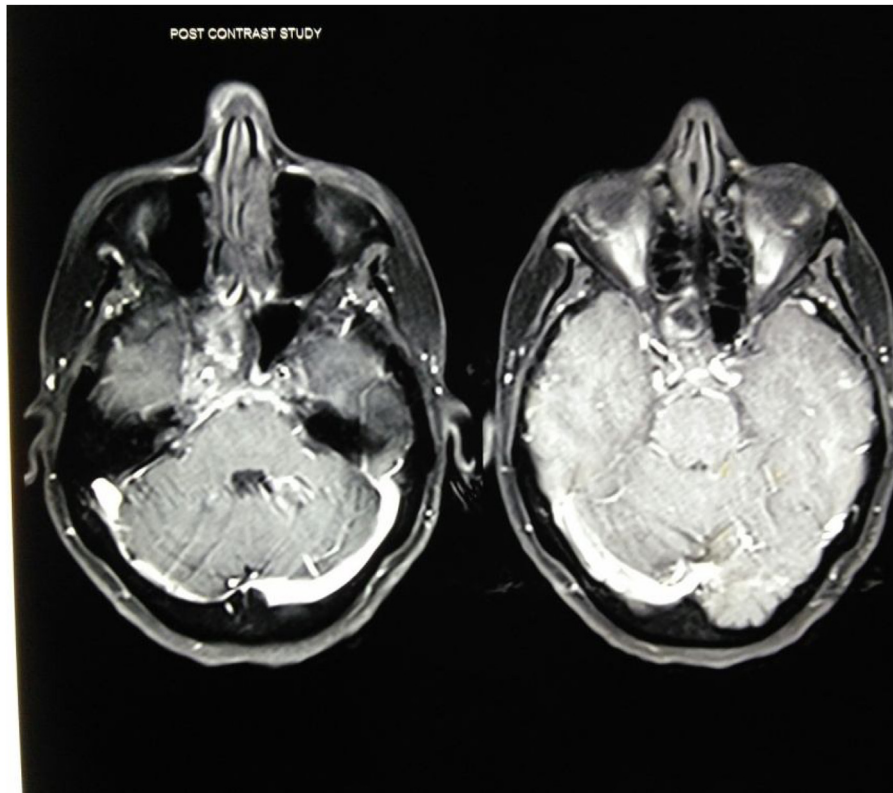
MRI brain T1WI showing post-contrast enhancement.
